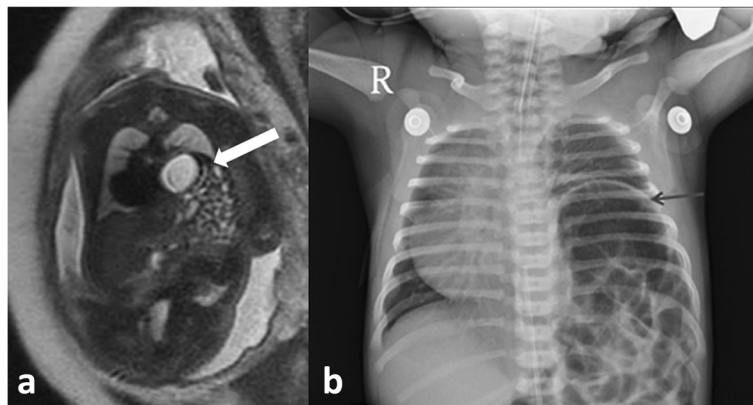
Thirty-three-year-old G2 P1 L1 at 32 weeks of gestation with features of left-sided eventration. a Coronal T2-weighted MRI image of fetal trunk showing the presence of stomach and small and large bowel loops in the thoracic cavity with an intact diaphragm (white arrow). b Postnatal chest radiograph showing elevated left hemidiaphragm (black arrow) outlined by the lung superiorly and bowel gasses inferiorly
